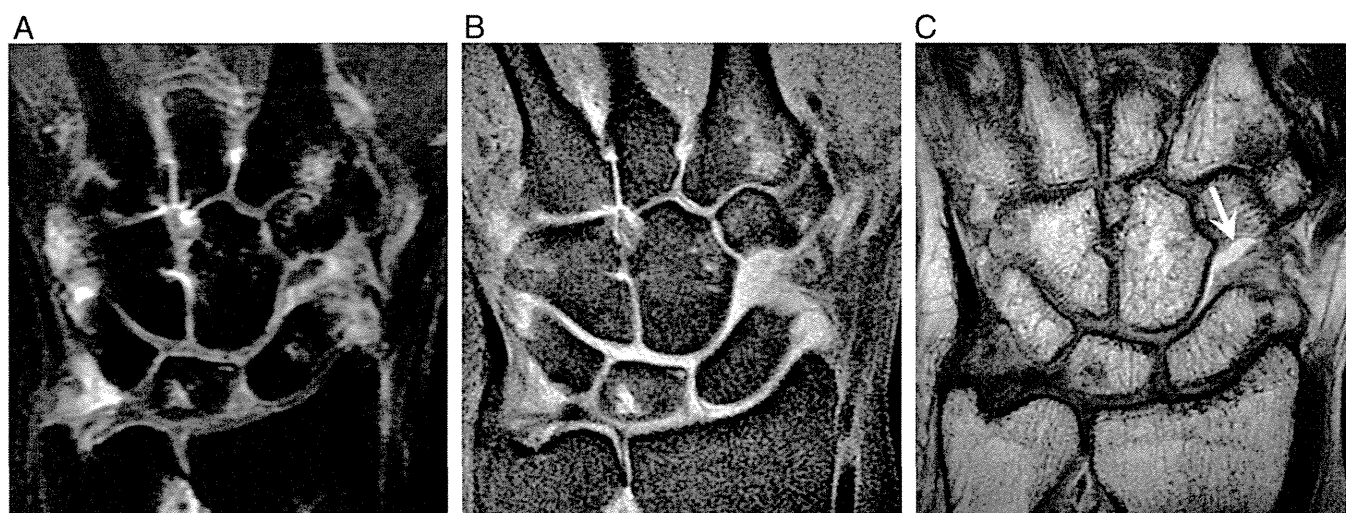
Early rheumatoid arthritis in a 64-year-old woman. Fat-suppressed gadolinium-enhanced T1-weighted image of the left wrist (A) shows marked periarticular enhancement and bone erosions of carpal bones. Fat-suppressed intermediate-weighted FSE image (B) also depicts the inflamed synovium and bone erosions. In addition, fast imaging employing steady-state acquisition (FIESTA) image (C) delineates a joint fluid (arrow).
